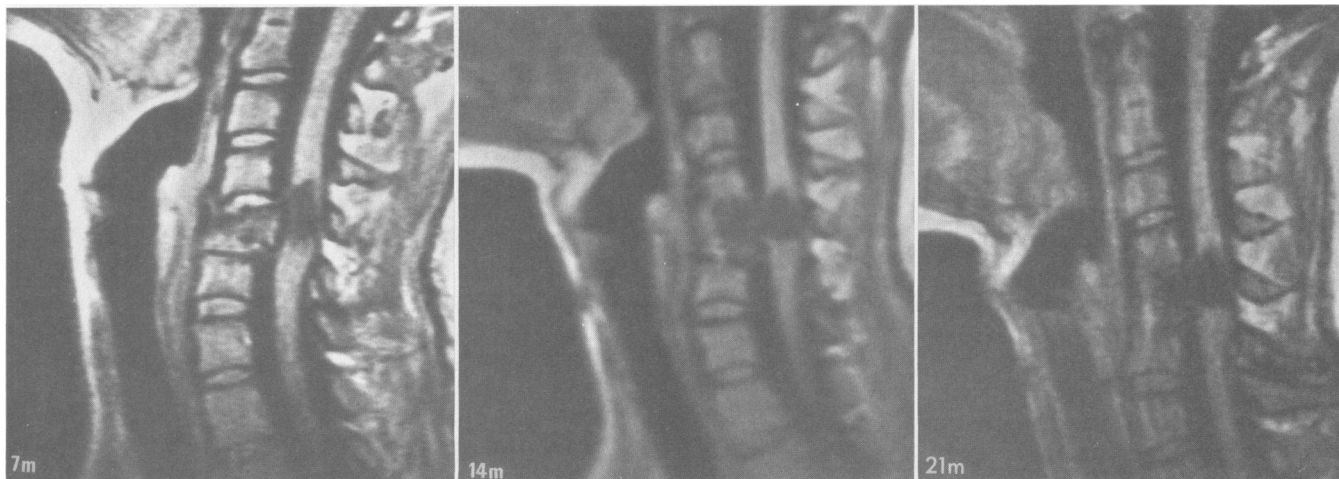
Case 7: Serial magnetic resonance imaging scans dated 7 months (left), 14 months (middle), and 21 months (right) after a cervical flexion injury. The anatomic evolution of this posttraumatic spinal cord cavity is clearly delineated.
